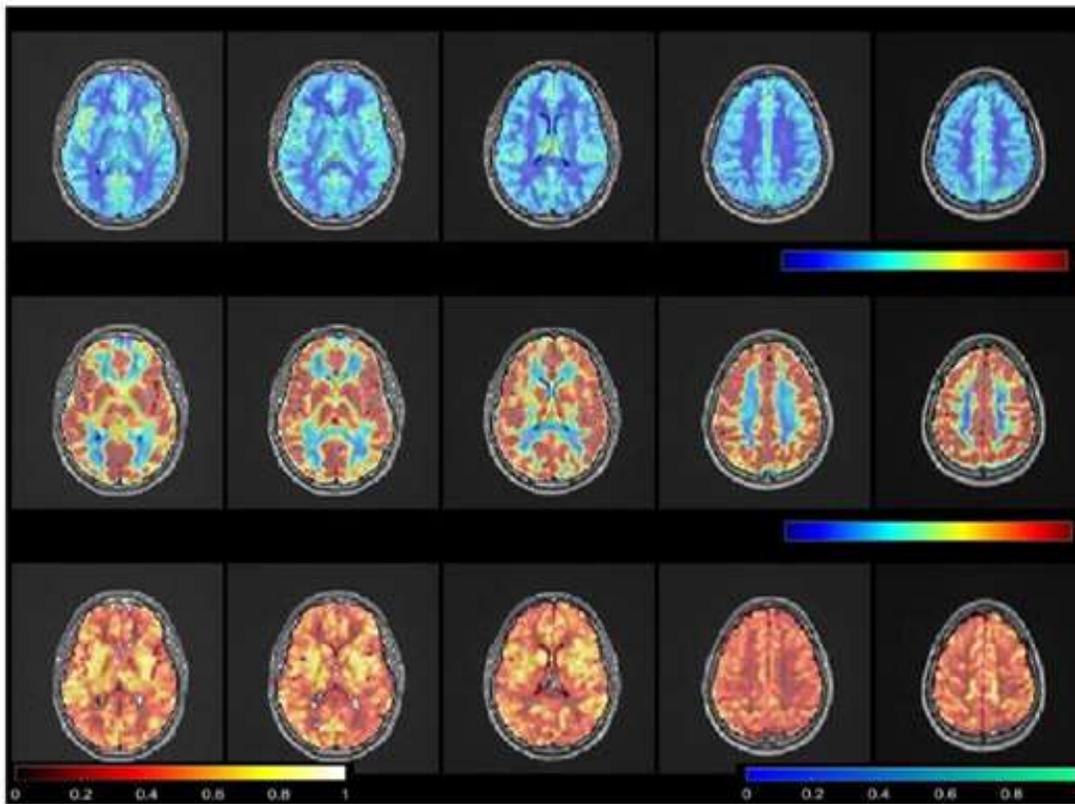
Changes in brain perfusion associated with HBOT 100% oxygen at 1.5 atmosphere absolute in a 19 yr. old young adult. SPECT Images are presented as % of maximum brain activity (upper two rows). The upper panel shows minimal perfusion, evidenced by the blue color. The second row shows much improved perfusion in red. The bottom row represents the % change in brain activity after HBOT. These changes were paralleled by steep improvement in cognitive functions and behavior.
